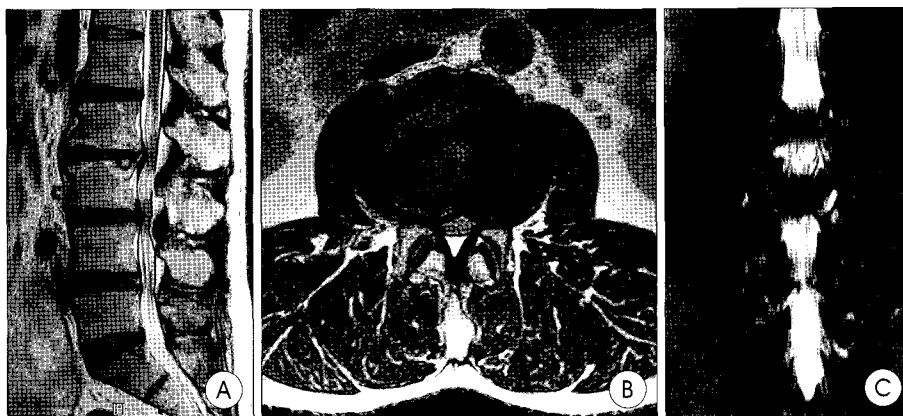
Magnetic resonance images (A, B) and magnetic resonance myelography (C) showing severe spinal stenosis at the L2-3 and L3-4 levels. Note the narrow cross-sectional area at the L2-3 level.
